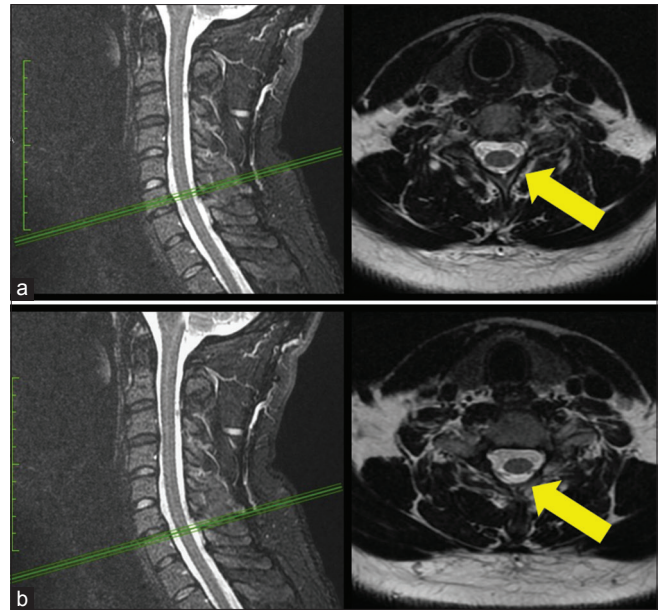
Axial views of the T2 weighted MRI images. In both (a and b) a normal level with the ligamentum flavum is observed. (b) blue arrow showing the ligamentum flavum. (c and d) the injured level, and the absence of the ligamentum flavum at that segment pointed by the arrow.
